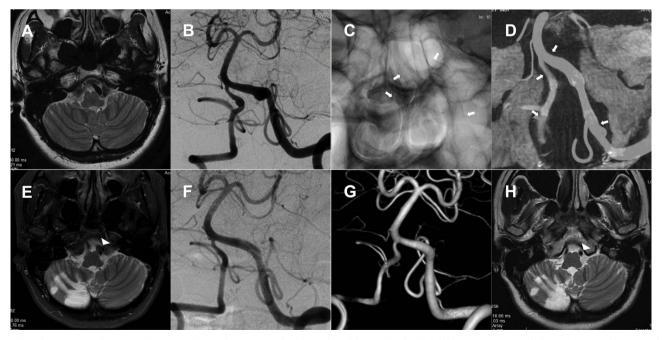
Bilateral VBDAs treated by PED implantation without coils. A Pre-procedural T2WI showed flow void in the dilated left VA; B Angiogram of left VA with retrograde contrast filling into the right VA, showed bilateral VBDAs; C Image showed implanted PEDs (white arrows); D Dual volume reconstruction after bilateral PED implantation (white arrows); E T2WI at 6-week follow-up showed infarction in the right PICA territory, and the thrombosed portion of the left VBDA (white arrow head); F/G Angiogram and 3D reconstruction at 12-month follow-up showed total occlusion of bilateral VBDAs, and patency of bilateral PICAs; H T2WI obtained at the 29-month follow-up showed total regression of the aneurysm in the left VA (white arrow head). (Dilation of the right VA was not apparent on either pre-procedural or post-procedural MRI).
